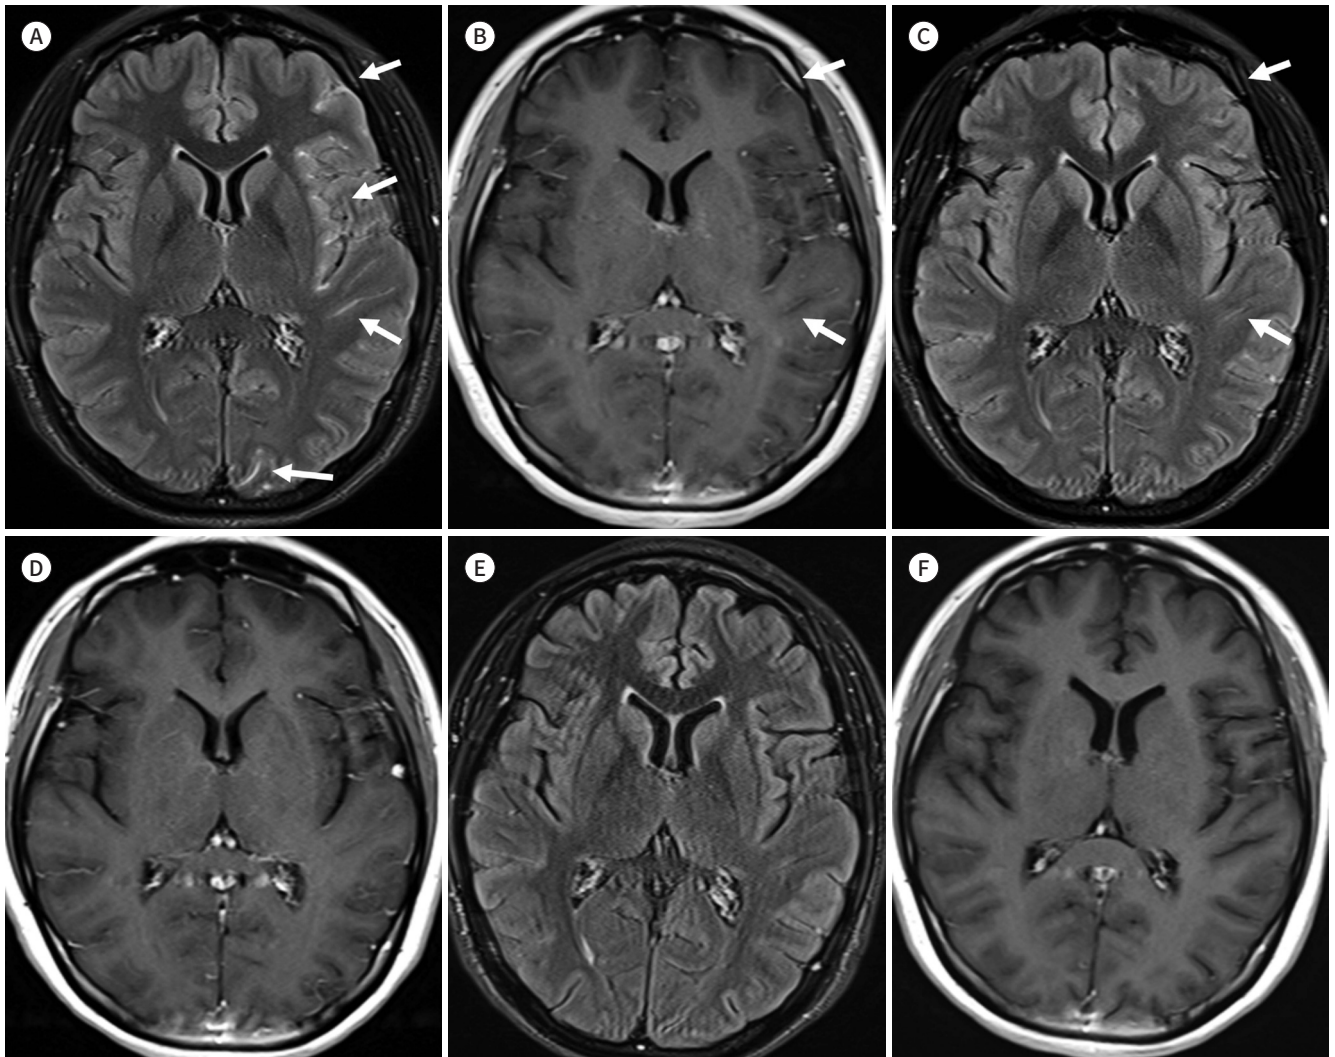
MRI of anti-NMDAR encephalitis in a 23-year-old female.
